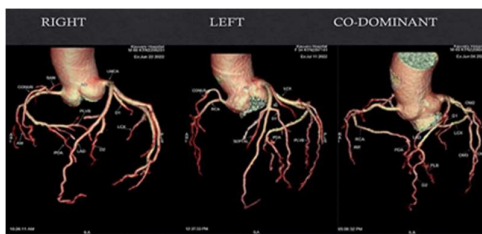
Normal Coronary artery anatomy- Left to Right: Right Dominant, Left Dominant and Co-Dominant. (3D CT coronary Angiogram)
